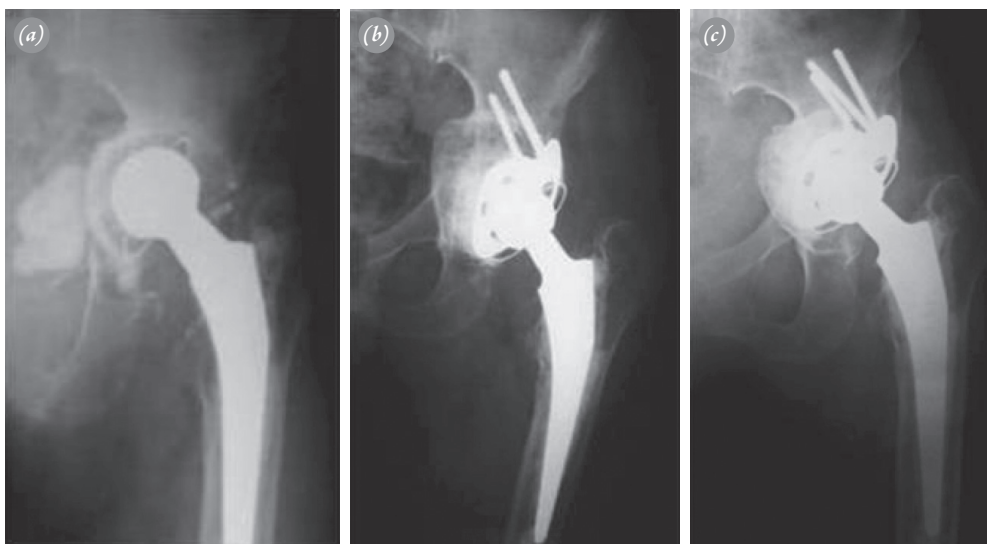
(a) Medial migration of the acetabular component and acetabular component loosening, (b) direct radiograph at Month 6 postoperatively after reconstruction with ARR and allografts, (c) breakage of 1 screw without loosening at Year 5.
